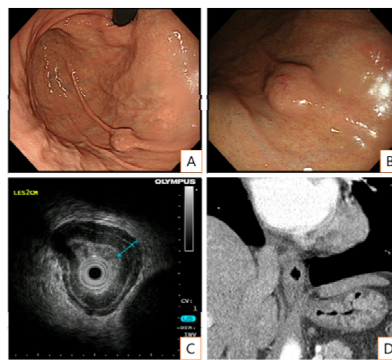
(A), (B) An approximately 1.5-cm sized sub-epithelial lesion with focal nodularity was noted on the great curvature side of the high body. (C) Endoscopic ultrasound showed a thickened esophageal proper muscle layer at the esophagogastric junction, suggesting a diagnosis of achalasia. (D) Computed tomography also showed esophageal wall thickening.
